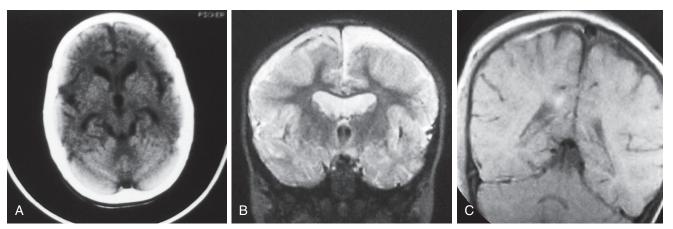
A and B, This 3-year-old abuse victim presented with lethargy, vomiting, hyporeflexia, and the acute onset of blindness. The CT scan reveals ventricular enlargement and cortical atrophy, which were the result of severe shaking 1 year earlier, but no hemorrhage. His MRI shows small, bilateral subdural hemorrhages that were missed on CT. C, This 5-month-old infant with head and facial bruises, bilateral retinal hemorrhages, and multiple rib fractures was found to have subdural hemorrhages of differing ages on MRI. The white subdural hematoma is between 0 and 14 days old, and the gray subdural hematoma is more than 14 days old. (*Courtesy Randall Alexander, MD, Moorehead School of Medicine, Atlanta, Ga.*)
